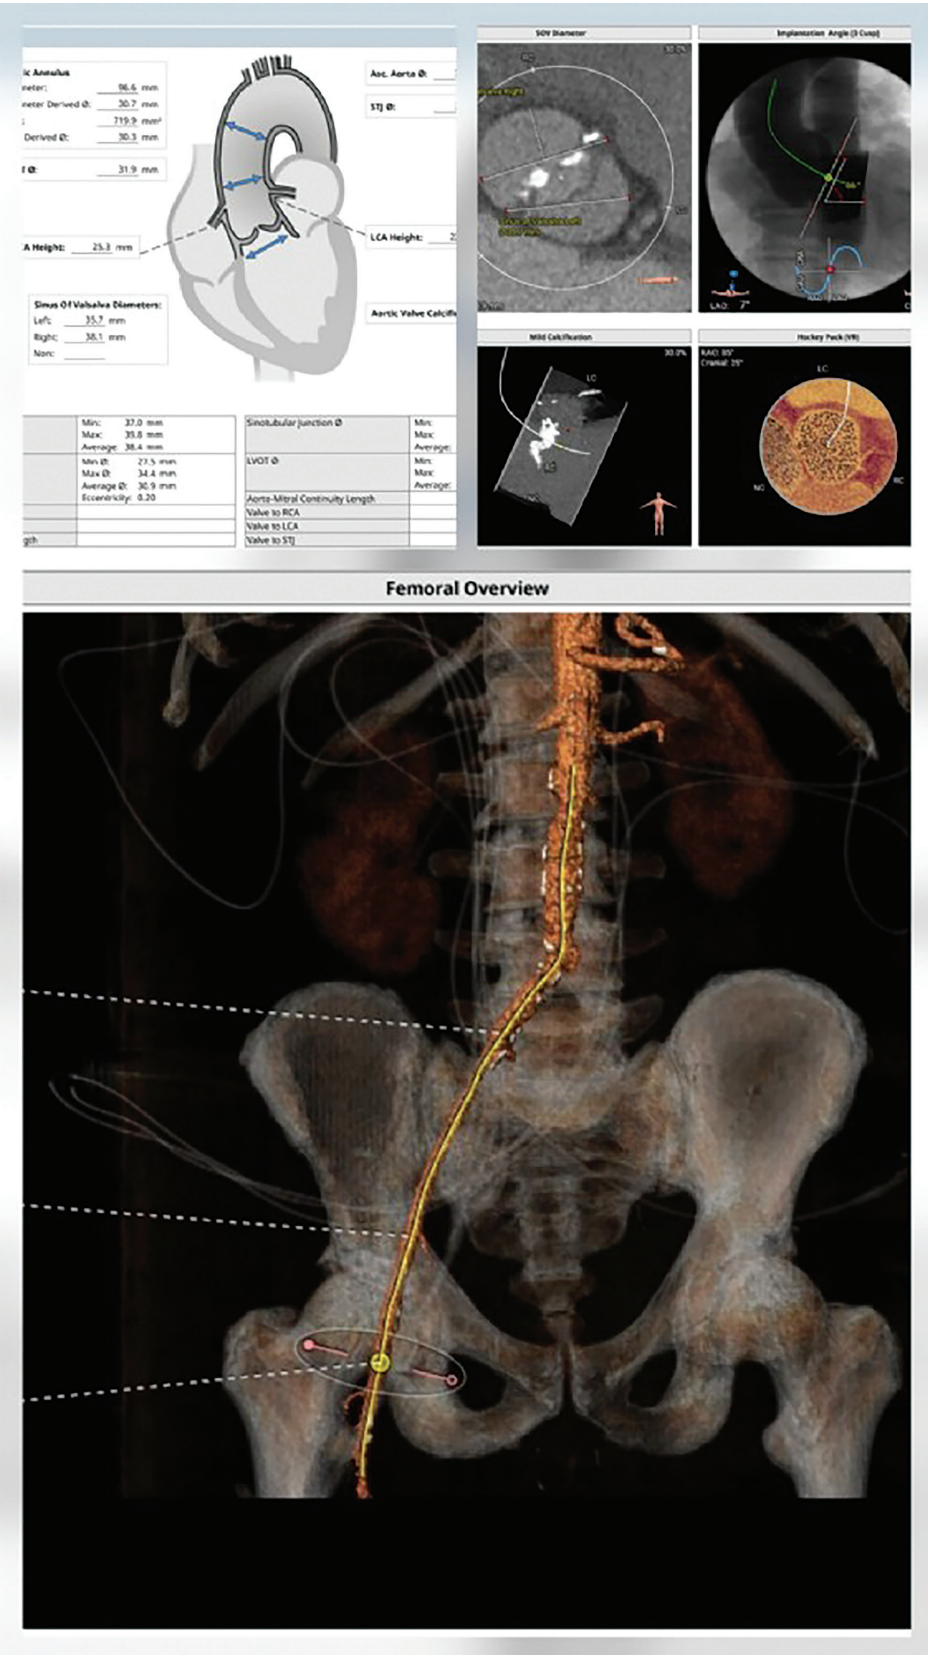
Computed tomography scans
